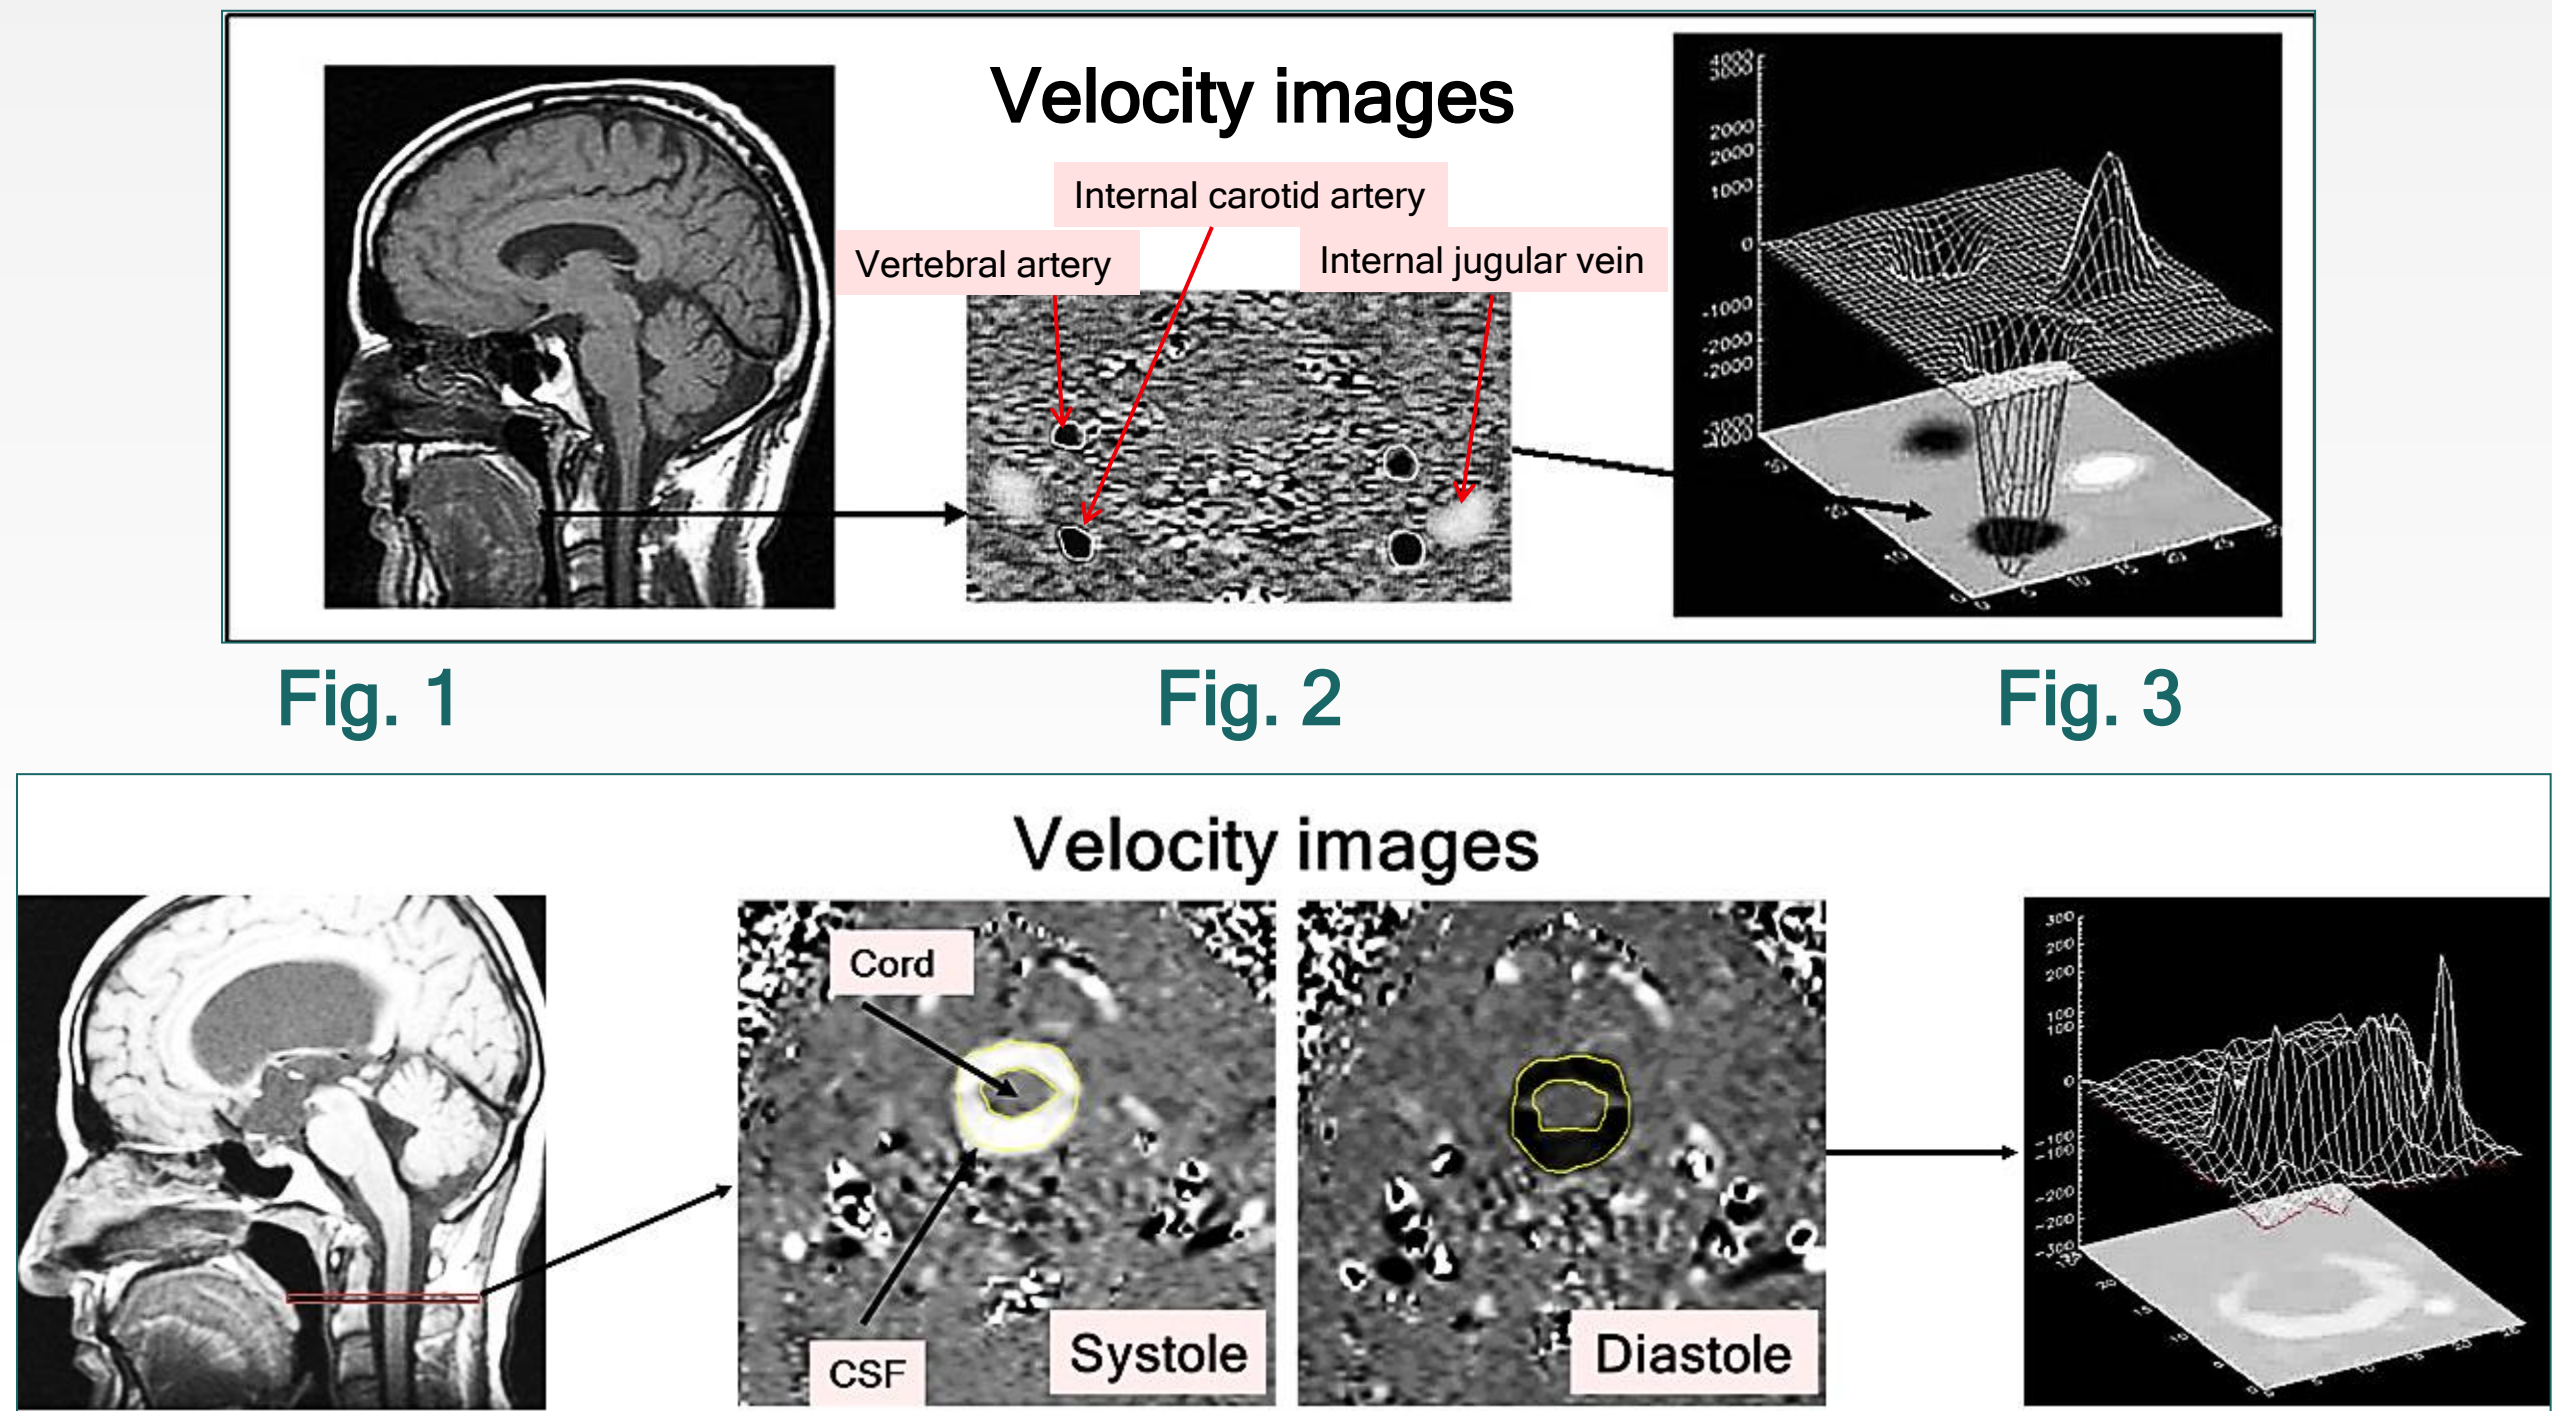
Shows a 'scout' lateral MRI image. Note the transverse line. The velocity encoded image obtained from this region is Fig 2.
